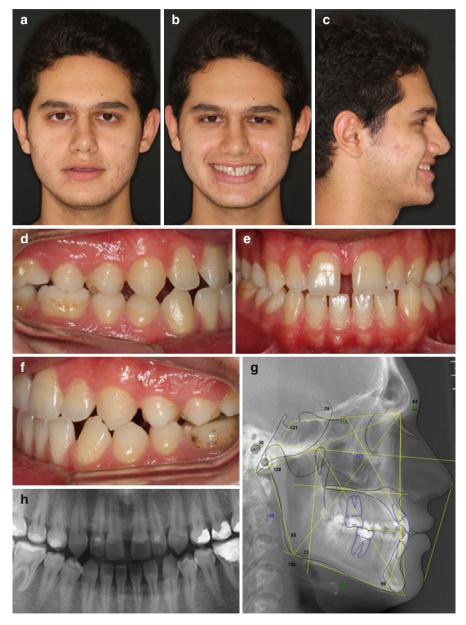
(a–c) Pretreatment extraoral photographs, (d–f) pretreatment intraoral photographs, (g, h) pretreatment radiographs
